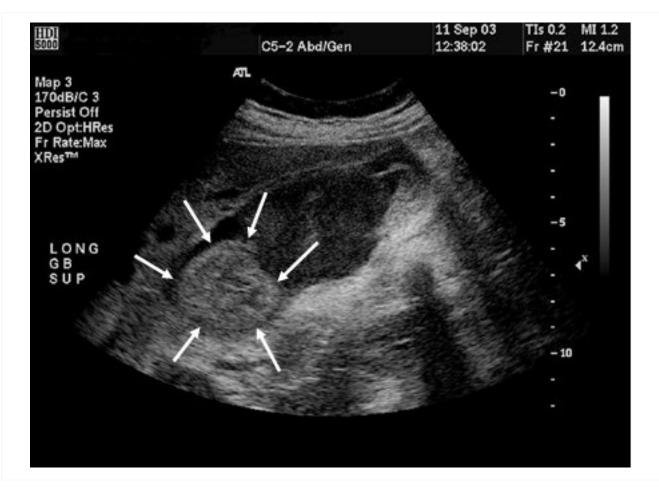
Gallbladder ultrasound of mass (arrows)
